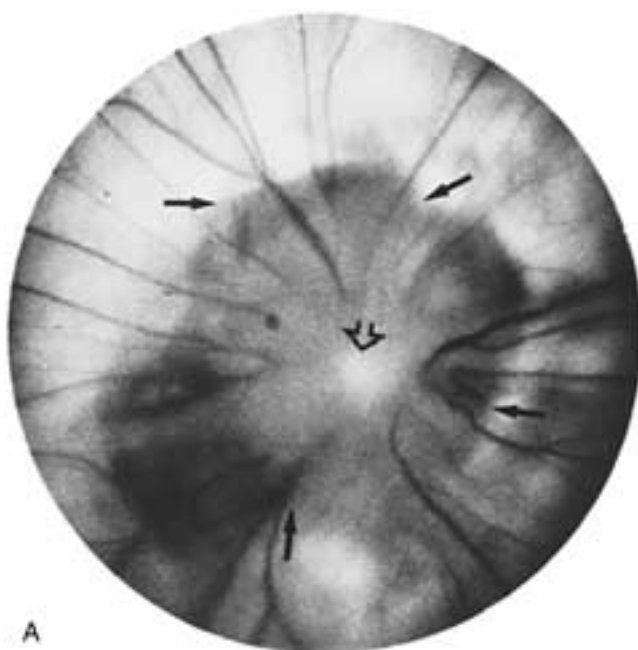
Morning glory anomaly. A, Disc is enlarged (solid arrows) and has a central core of white glial tissue (open arrows). B, Axial CT scan shows a funnel-shaped deformity of the posterior globe (arrow). (From Mafee MF et al. CT of optic nerve colobomas, morning glory anomaly, and colobomatous cyst. *Radiol Clin North Am* 1987;25:693–699.)
